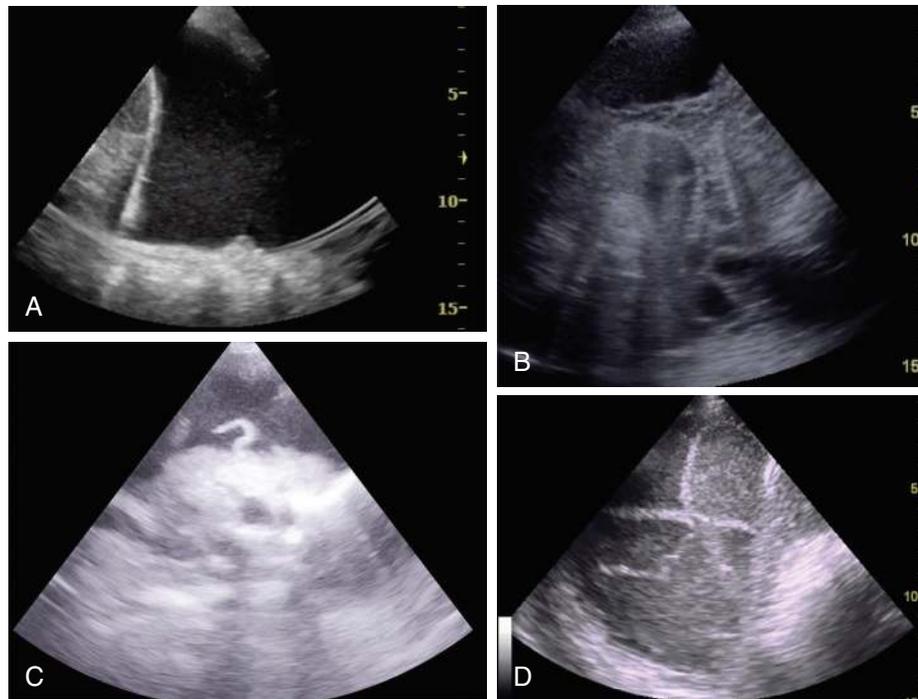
Point-of-care ultrasound of pleural space shows (A) anechoic simple effusion, (B) complex effusion with multiple septations, (C) complex effusion with debris (blood clot in this example), and (D) empyema with septations and increased echogenicity of pleural fluid.
